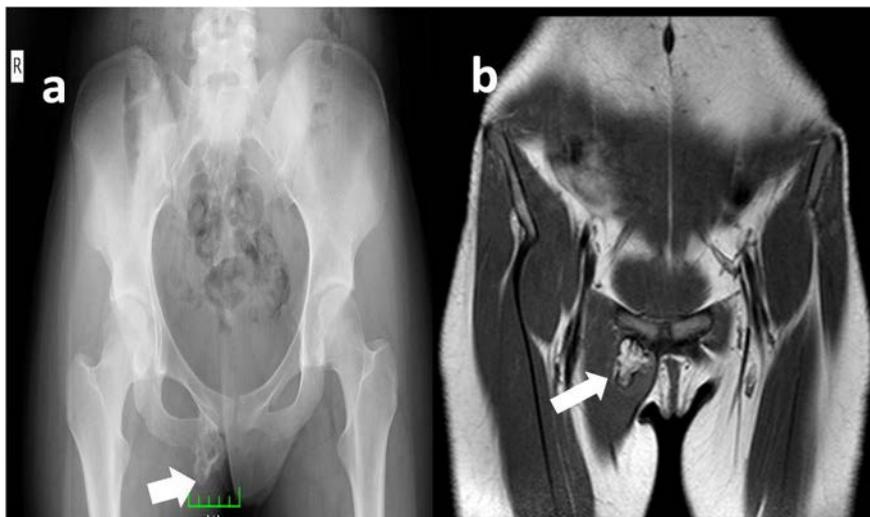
The solitary osteochondroma of pubic ramus is seen on antero-posterior pelvis radiography. 1b. The solitary osteochondroma of pubic ramus is seen on T2 weighted MRI sequence.
